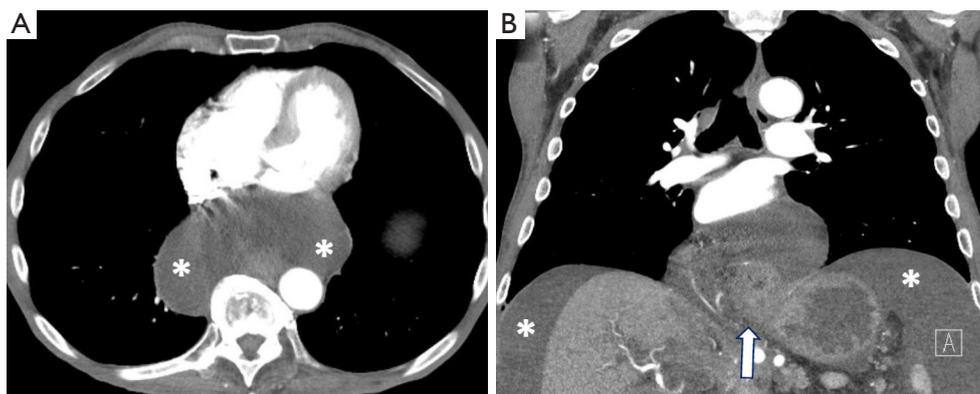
76-year-old male with ascending ascites. CT imaging demonstrates ill-defined hypoattenuation centered in the visceral compartment of the mediastinum (A, asterisks). No enhancement is present (A). Coronal image demonstrates the fluid is in continuity with abdominal ascites (B, asterisks). Note the hiatal hernia, a common finding in patients with ascending mediastinal ascites (B, white arrow). The hiatal hernia can also be faintly recognized in the selected axial image. CT, computed tomography.
